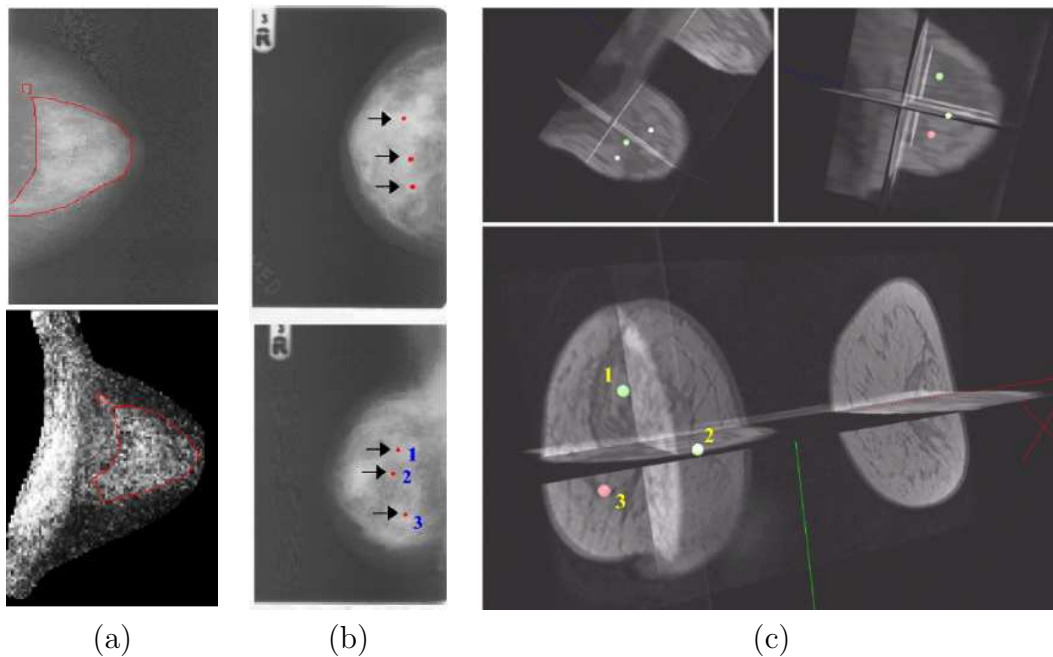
Behrenbruch's approach correspondence results: (a) pharmacokinetic (2-D) projection of the MR volume, (b) lesion localisation in X-ray images and (c) its correspondence in MR volume.
